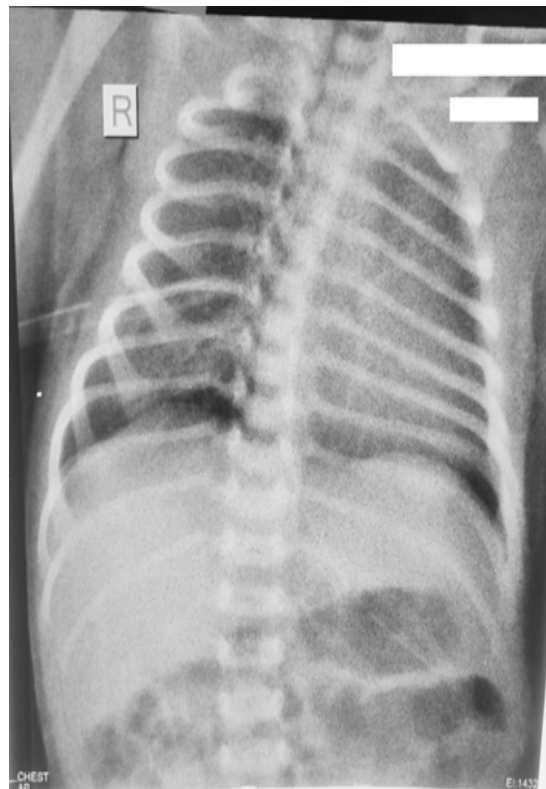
Chest Xray Ap view showing resolution of Pneumothorax following IC tube insertion
